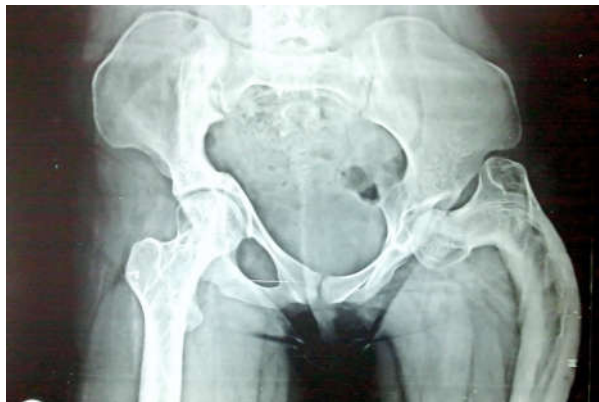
Preoperative radiograph case 2
